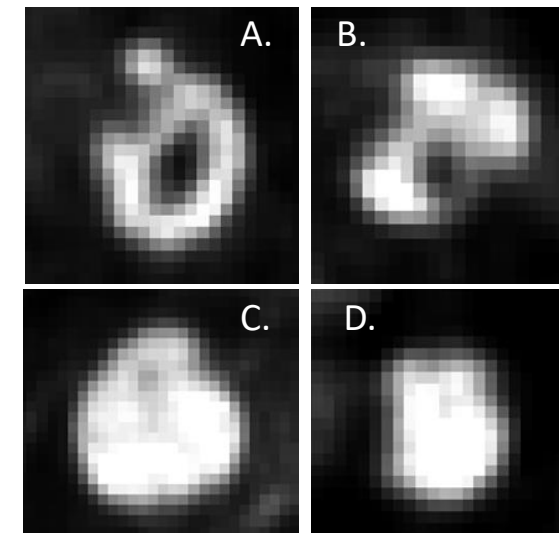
FDG PET images showing primary tumors from different stage III NSCLC patients. (A) and (B) have a high entropy indicating that the variability is high in neighborhood intensity values. (C) and (D) have a more homogeneous distribution of SUV within the tumor, which corresponds to a low entropy value. PET, positron emission tomography; NSCLC, non-small cell lung cancer; SUV, standardized uptake value.
